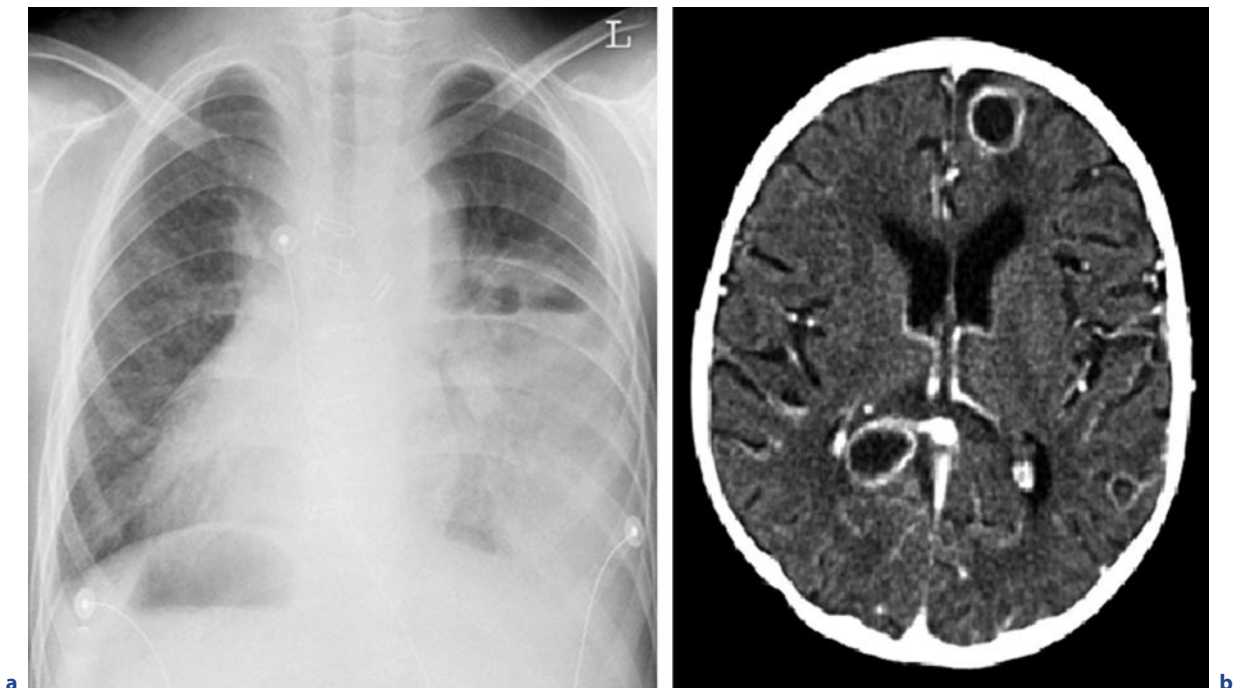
A 6-year-old boy; complex heart malformation (Situs inversus, single inlet/double outlet ventricle with transposition); after surgical correction. a Chest X-ray. b Contrast-enhanced CT. c,d see next page
